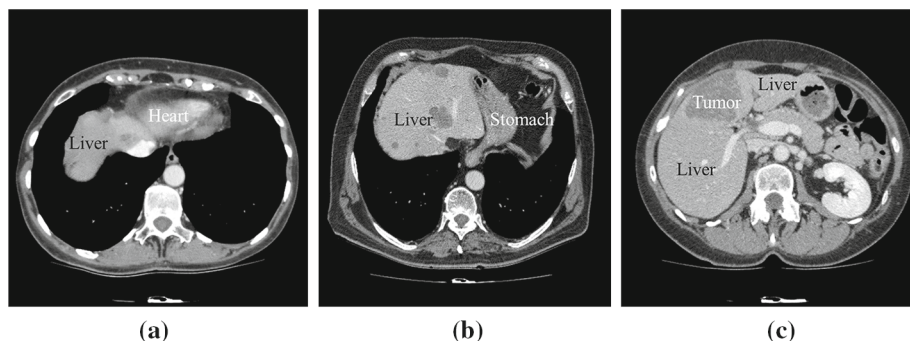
Examples of difficulties of liver segmentation: sample CT slices with ambiguous boundary between liver and heart (a), stomach (b) and tumor must be included in segmentation (c)
